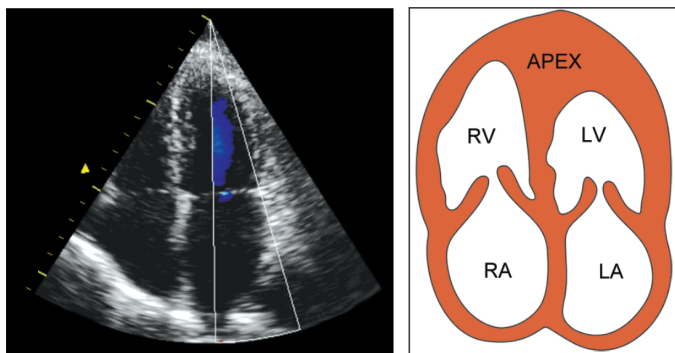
Apical 4-chamber view showing:
